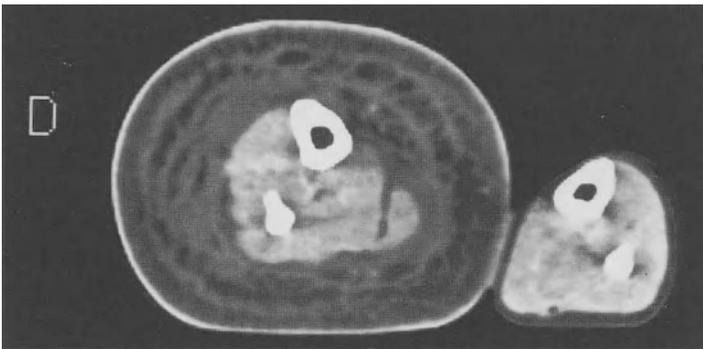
The same patient as in Fig. 28. CT scan of both legs
